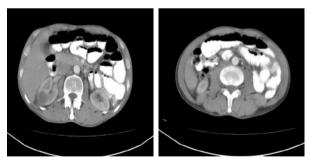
CT images with acute MBO due to postoperative adhesion.
